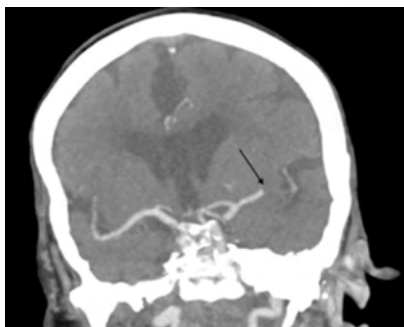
CT angiogram showing left MCA occlusion (arrow).
